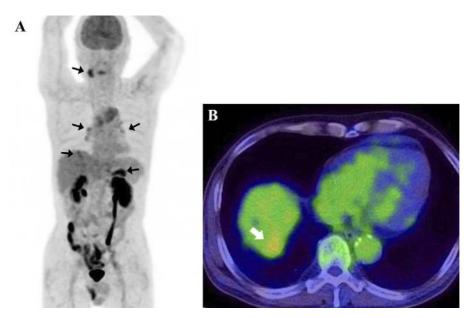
18 F-FDG PET/CT findings in 2017. (A) Maximum-intensity projection image showed an abnormal 18 F-FDG uptake in the hepatic tumor lesion (SUV_{max} 3.4), right submandibular gland (SUV_{max} 4.7), bilateral hilar lymph nodes (SUV_{max} 3.2), and remnant pancreatic tail (SUV_{max} 5.5) (the abnormal uptake is indicated by arrows). (B) Hepatic tumor lesion on PET/CT axial image (white arrow). 18 F-FDG: 18 F-fluorodeoxyglucose, CT: computed tomography, PET: positron emission tomography, SUV_{max}: maximum standardized uptake value
